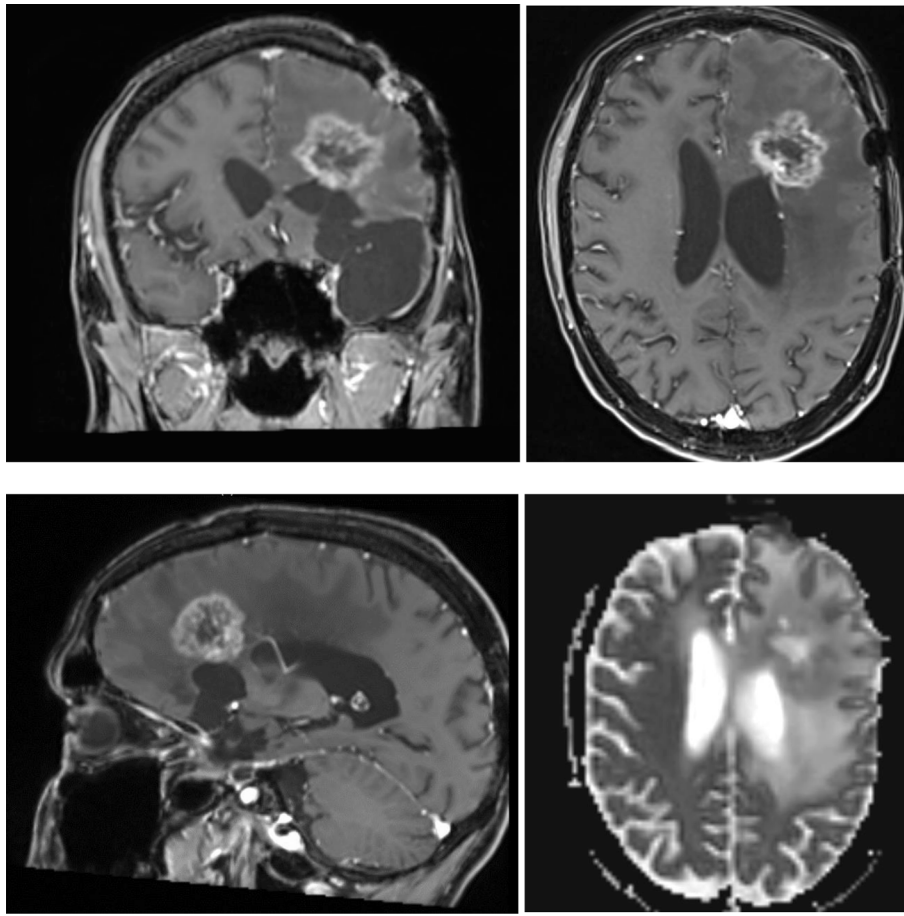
August 2019: MRI (T1 with contrast corona, axial, sagittal and ADC axial), further progress, indication for surgery.
